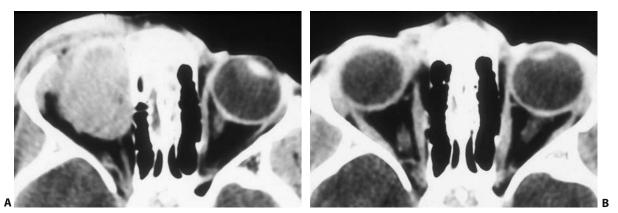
(A) Computed radiographic tomogram of orbital rhabdomyosarcoma. (B) After treatment with a combination of chemotherapy and external beam irradiation, the tumor demonstrated complete regression and long-term local control. (Courtesy of Dr. Aaron Rausen of New York City.)
